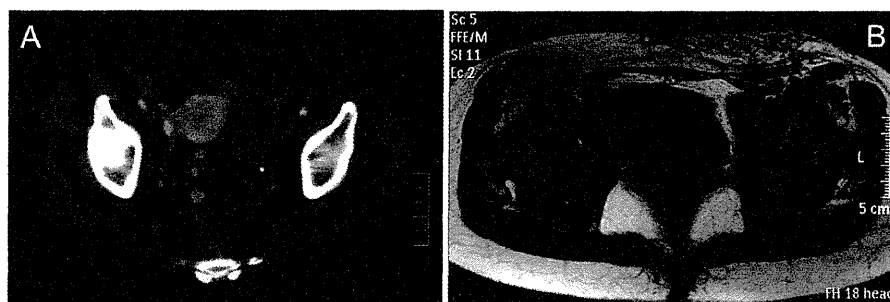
Representative images of lymphangioliomyomas in the pelvic cavity and lymphedema of the lower abdominal skin (patient #7, JUL 221). Computed tomography of the pelvic cavity after intravenous injection of contrast material revealed cystic lymphangioliomyomas along the left internal iliac vessels (A). T1-weighted MRI axial images without contrast material demonstrated thickening and fluid accumulated in the subcutaneous tissue of the left lower abdominal skin (B).
